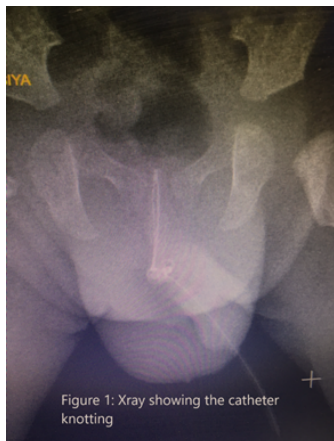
Xray showing the catheter knotting
